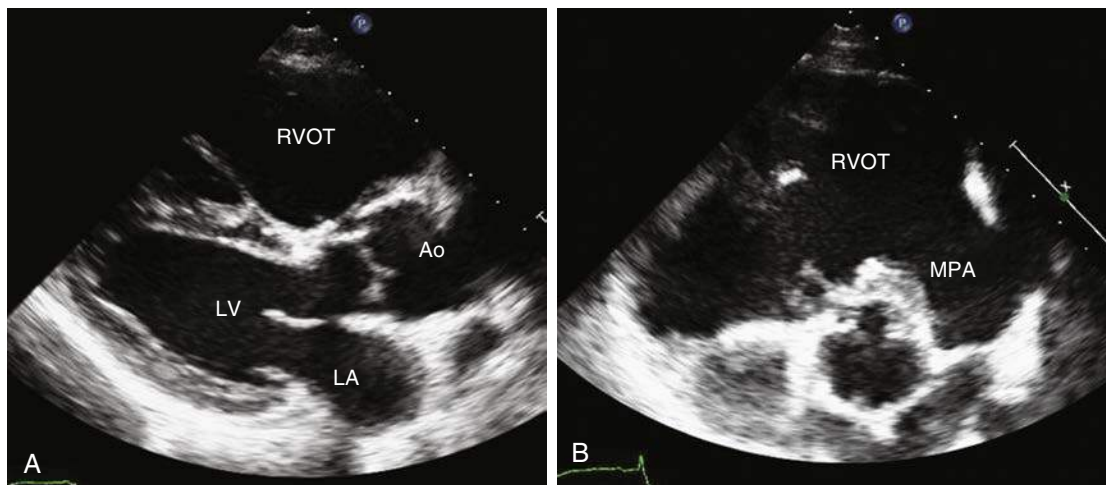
Two-dimensional transthoracic echocardiography from a patient with repaired tetralogy of Fallot. A, Parasternal long-axis view showing dilated right ventricle. B, Parasternal short-axis view demonstrating aneurysmal dilation of the RVOT and absence of functional pulmonary valve tissue. Ao, Aorta; LA, left atrium; LV, left ventricle; MPA, mean pulmonary artery; RVOT, right ventricular outflow tract.
